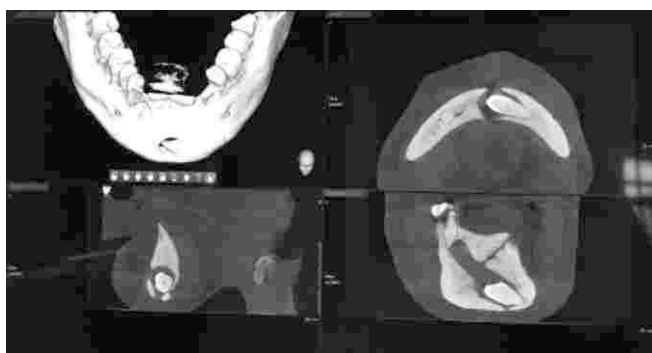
CBCT image showing pathological fracture in symphysis region and impacted 33 and 43.
